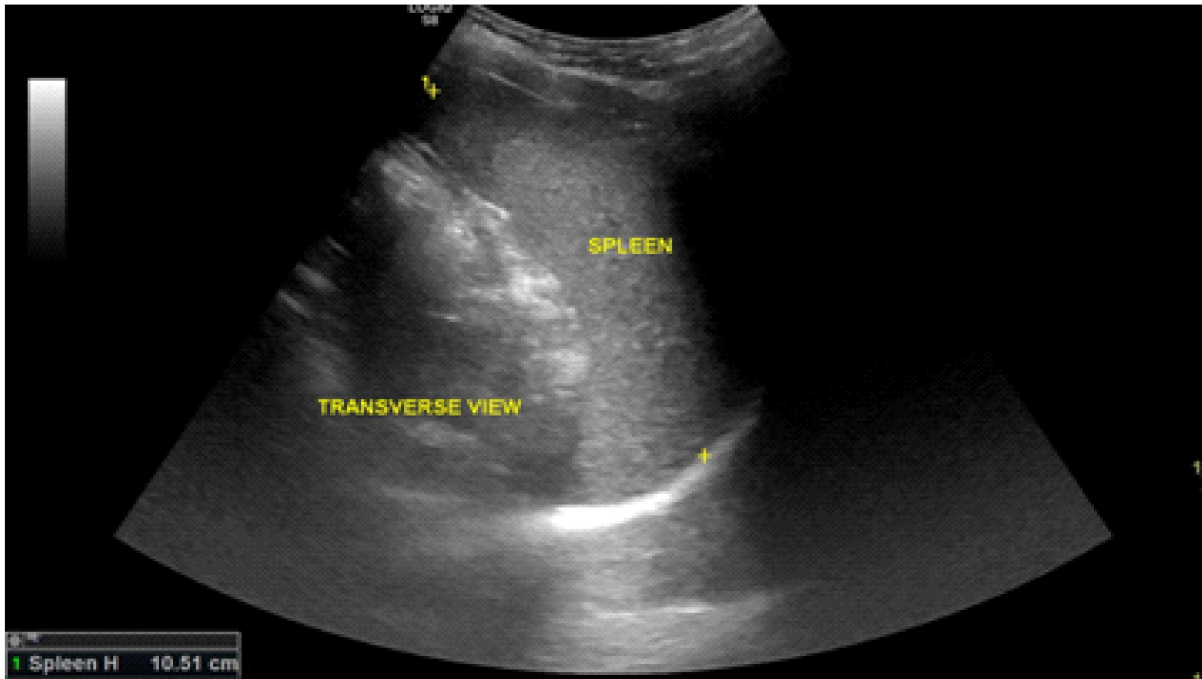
B-mode abdominal ultrasound of the spleen showing the measurement of the transverse diameter (calipers)
